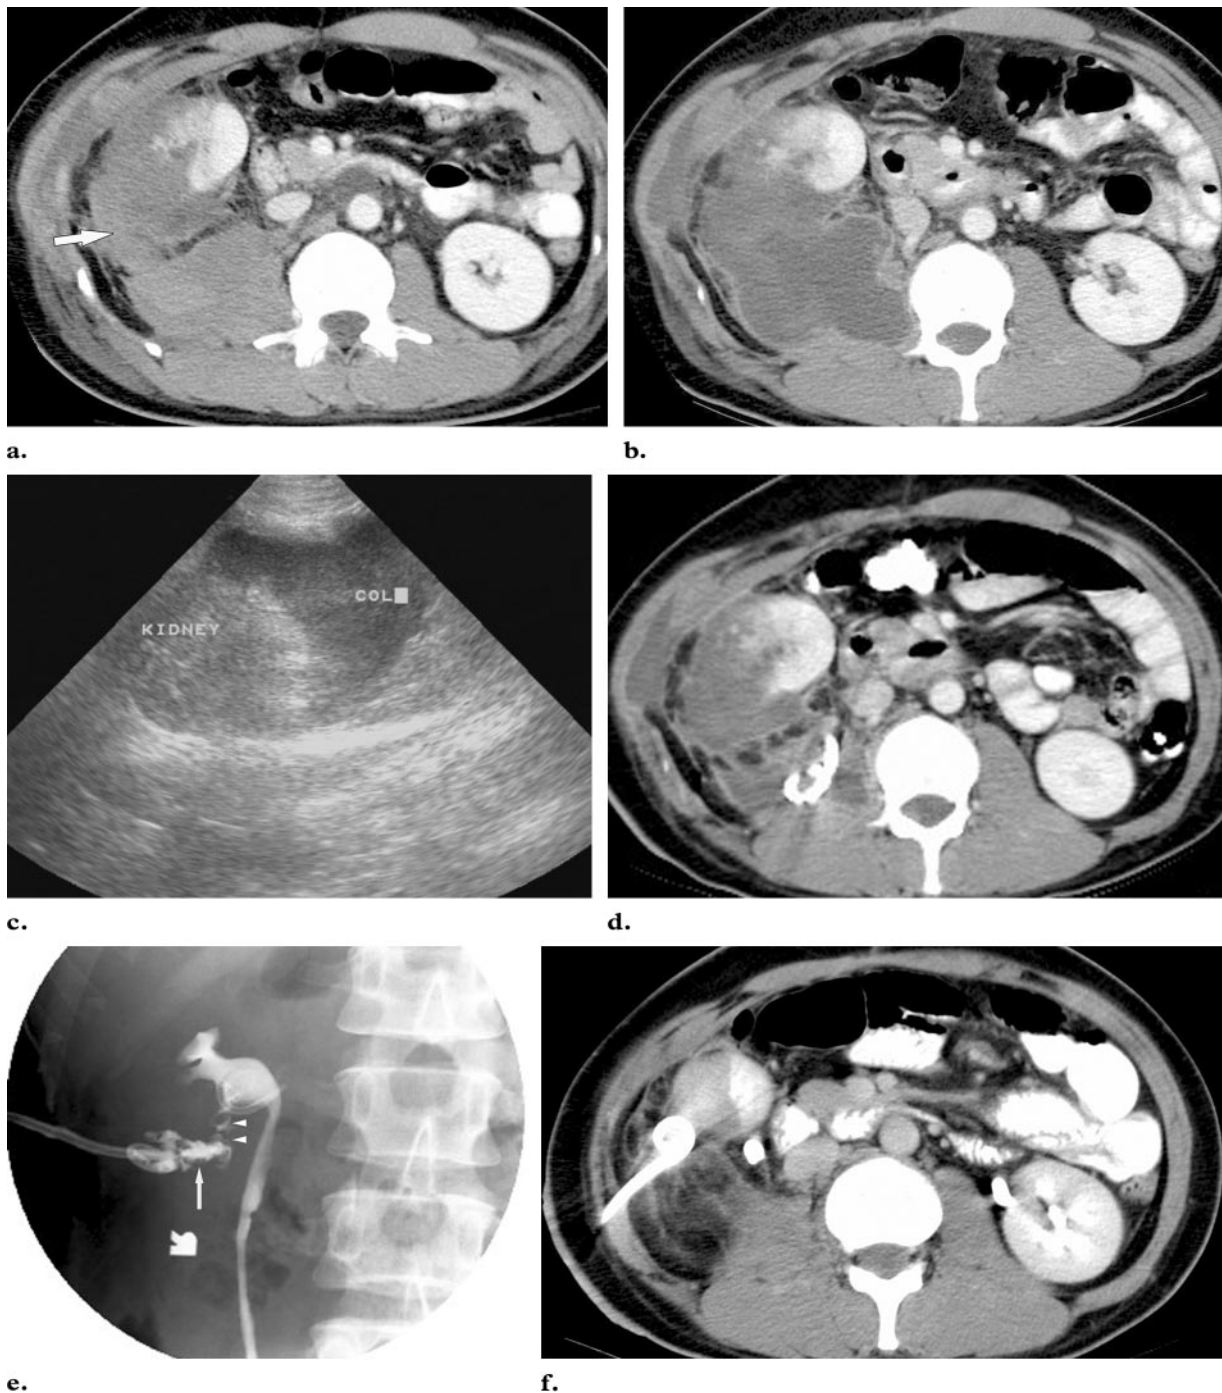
Renal urinoma in a 39-year-old man who sustained right renal trauma from a stab wound. (a) Contrast-enhanced CT scan shows a fracture of the right kidney and a surrounding perinephric fluid collection (arrow). (b) On a contrast-enhanced CT scan obtained 7 days later, the perinephric fluid collection has increased in size and now demonstrates a high-attenuation rim. Percutaneous drainage of the presumed liquefied and infected hematoma was performed. (c) Sagittal US image obtained on the same day as b shows a fluid collection inferior to the right kidney. An 8-F drainage catheter was placed under US guidance. (d) Contrast-enhanced CT scan obtained 7 days after c shows a smaller but persistent perinephric fluid collection. High-volume catheter outputs persisted. Evaluation of the creatinine level of the fluid collection confirmed the diagnosis of urinoma. Antegrade ureteral stent placement was performed. Contrast material was injected through the percutaneous drainage catheter 5 days later due to decreased catheter output. (e) Pyelogram shows that the size of the urinoma cavity has decreased (arrow), but that communication between the percutaneous urinoma drainage catheter and the renal collecting system persists (arrowheads). (f) Contrast-enhanced CT scan obtained 10 days after e shows interval resolution of the perinephric urinoma. The combined use of the urinoma drainage catheter and ureteral stent promoted healing of the collecting system.
